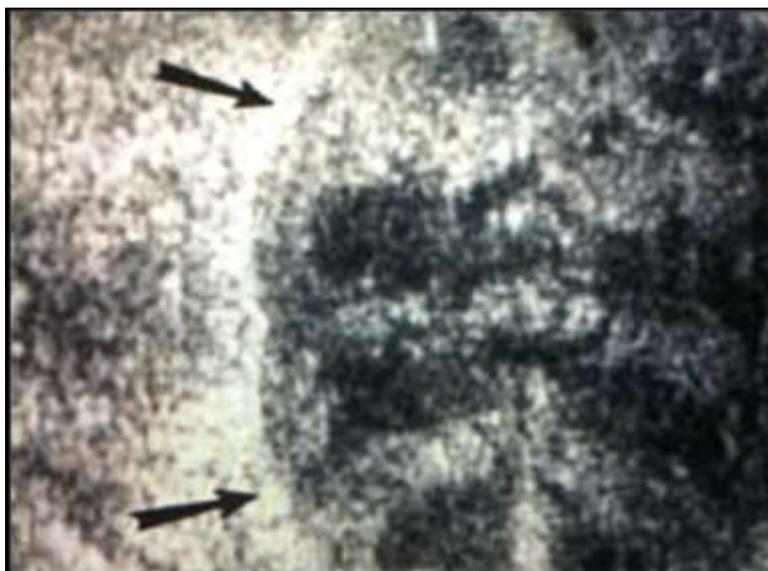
An ultrasound image of adrenal gland showing an enlarged, lobulated gland. It has a “cribriform” appearance on a newborn with congenital adrenal hyperplasia due to 21-hydroxylase deficiency.
